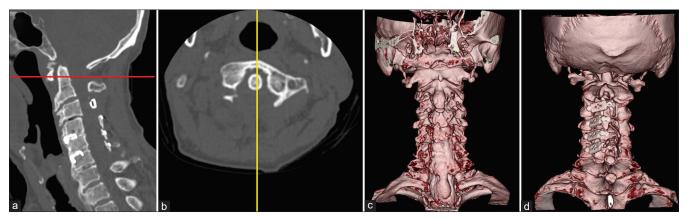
Latest postoperative computed tomography (CT) of sagittal-view (a) and axial-view (b) showed C1 laminectomy, cervical laminoplasty, anterior cervical fusion, and no anterior arch fracture of C1. (b) was at the level of the red line in (a). (a) was at the level of the yellow line in (b). Anterior view (c) and posterior view (d) three-dimensional CT scans.
